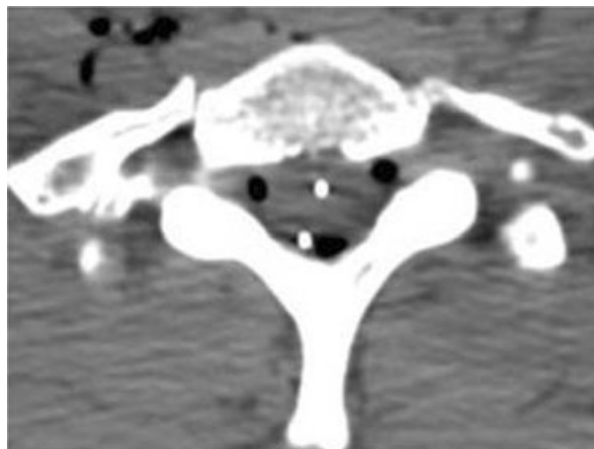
Computed tomography (CT) scan demonstrates two spinal cord stimulator leads in the cervical spine. The dorsal lead (the original implanted lead) is in the epidural space. The newly placed anterior lead is in the parenchyma of the cord.
